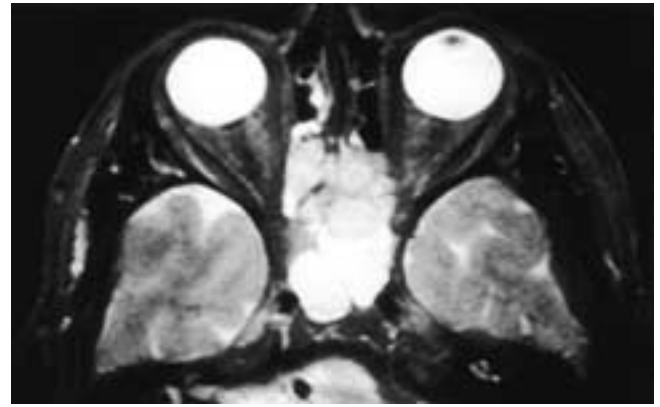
Axial T2-weighted MR image shows an intermediate signal intensity mass in the posterior ethmoid sinuses and anterior sphenoid sinuses. The remaining obstructed sphenoid sinuses are filled with high signal intensity secretions. This patient had a hemangiopericytoma.
